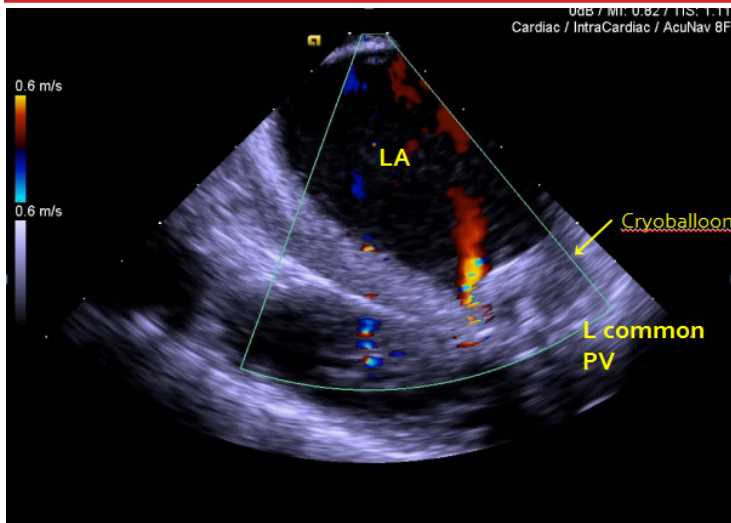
ICE imaging from the right atrium shows cryoballoon occluding most of the large common antrum of the left pulmonary veins, but with a small inferior leak detected by color Doppler (red flow from pulmonary vein into left atrium). LA = left atrium; PV = pulmonary vein.
